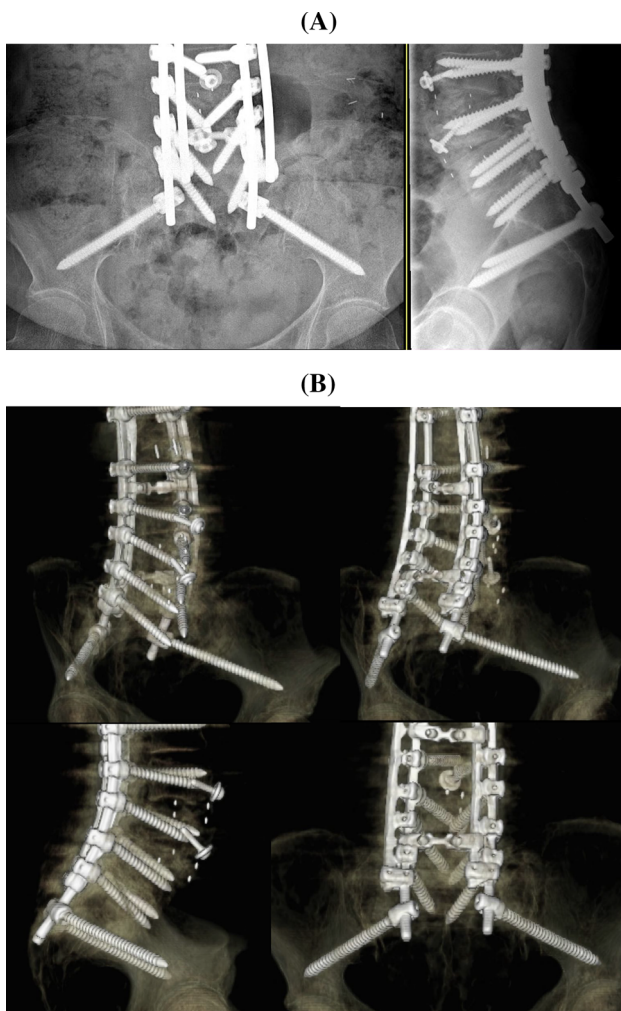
Patient #4: a 90 mm screw was used. No cortical breach was observed on postoperative plain radiographs or 3D CT scan
